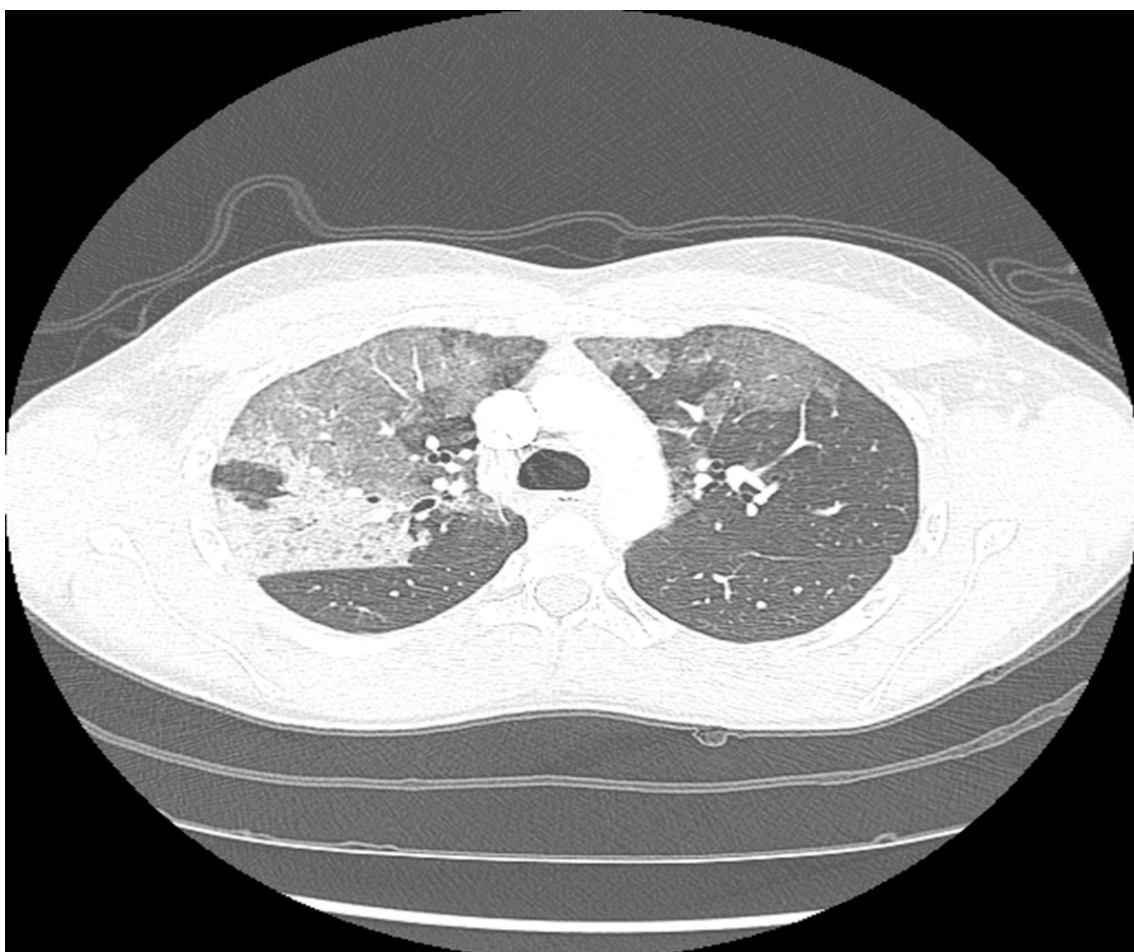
(27-07-2013 6h14pm) Computed tomography pulmonary angiography demonstrated ground glass opacities predominant within the right upper lobe of the lung, but also in the left superior lobe and the middle lobe.
